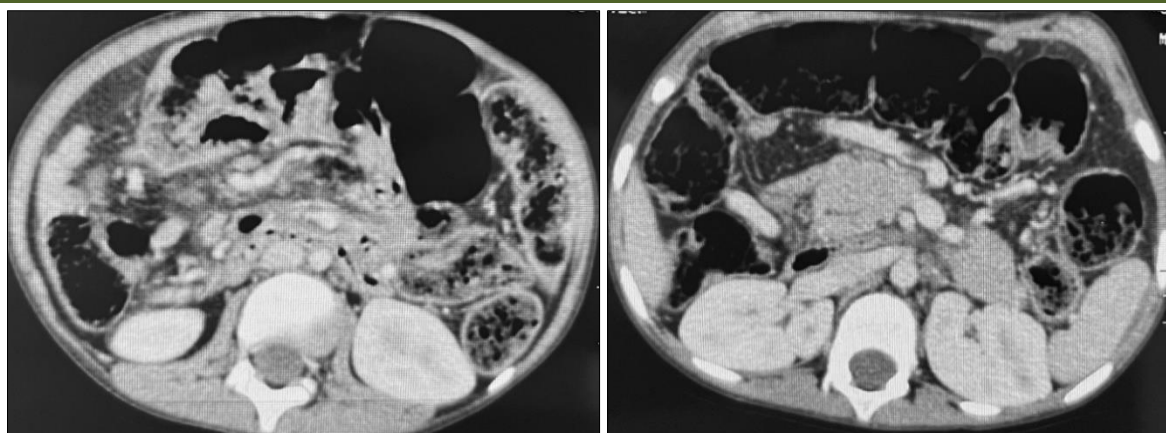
A follow-up CT Scan: No intra-abdominal collections.
